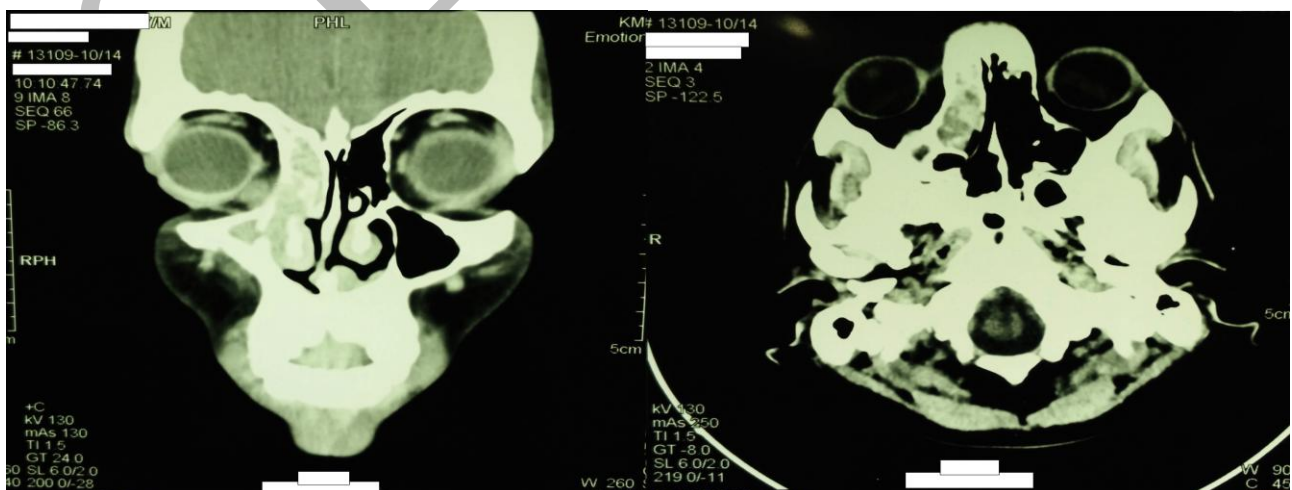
Contrast enhanced CT scan of PNS, Coronal and Axial views
